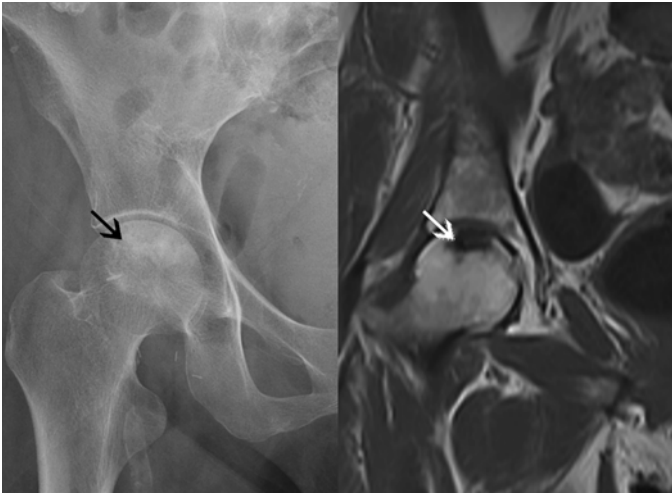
Anteroposterior radiograph of the right hip reveals subtle sclerosis (*black arrow*) representative of avascular necrosis. Coronal T1-weighted MR demonstrates serpiginous hypointensity (*white arrow*), confirming the diagnosis.
